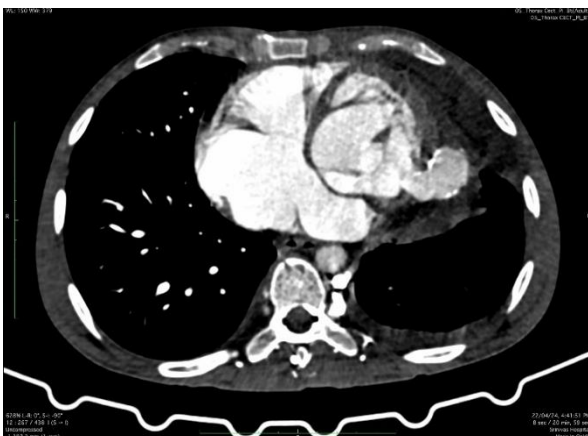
Contrast-enhanced CT chest showing contrast flow through the narrow neck into the pseudoaneurysm.
